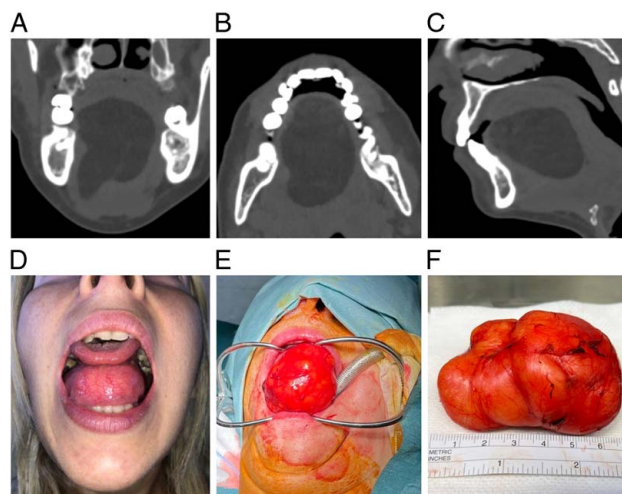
A-C, Lipoma of the floor of the mouth—pre-operative CT Scan. D, Lipoma of the floor of the mouth—pre-operative photo. E, Intraoperative photo—the view of surgical field during trans-oral surgery. F, Intraoperative photo—excised lesion.
